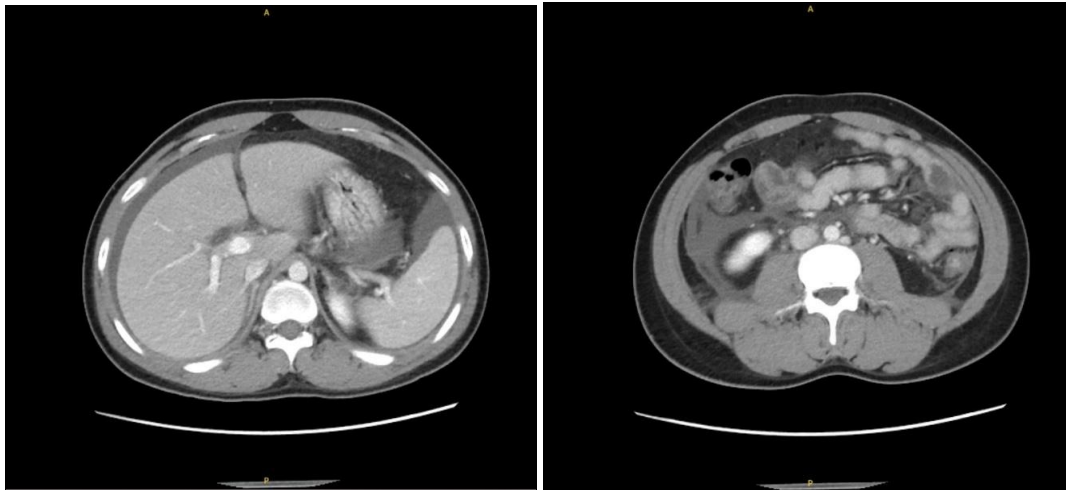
CT abdomen showing pelvi-abdominal ascites
